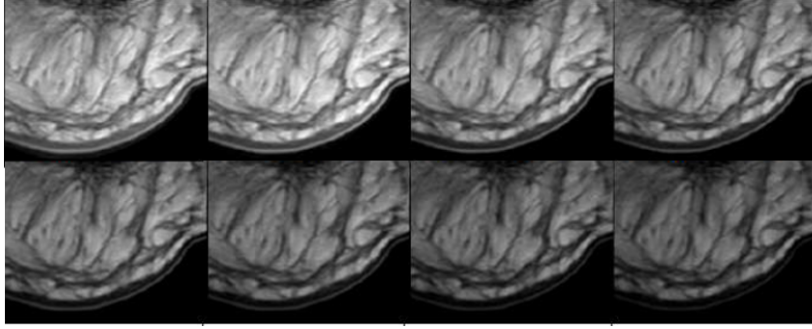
MRI sequence: Multi Spin Echo(MSE)calculation T2-weighted sequence
